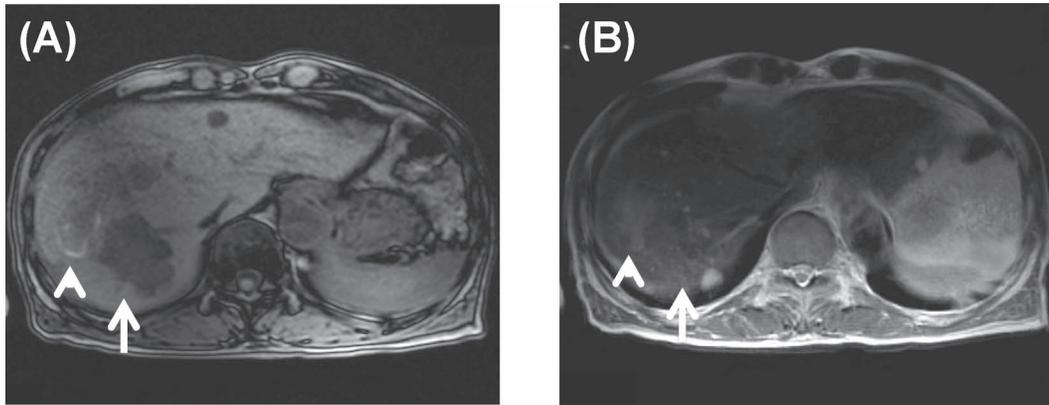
Magnetic resonance imaging revealed a 50-mm-diameter metastatic liver tumor in segment 7 on T1-weighted (A, arrow) and T2-weighted images (B, arrow) and multiple intrahepatic hematomas in the right hepatic lobe on T1-weighted (A, arrowhead), T2-weighted images (B, arrowhead).
